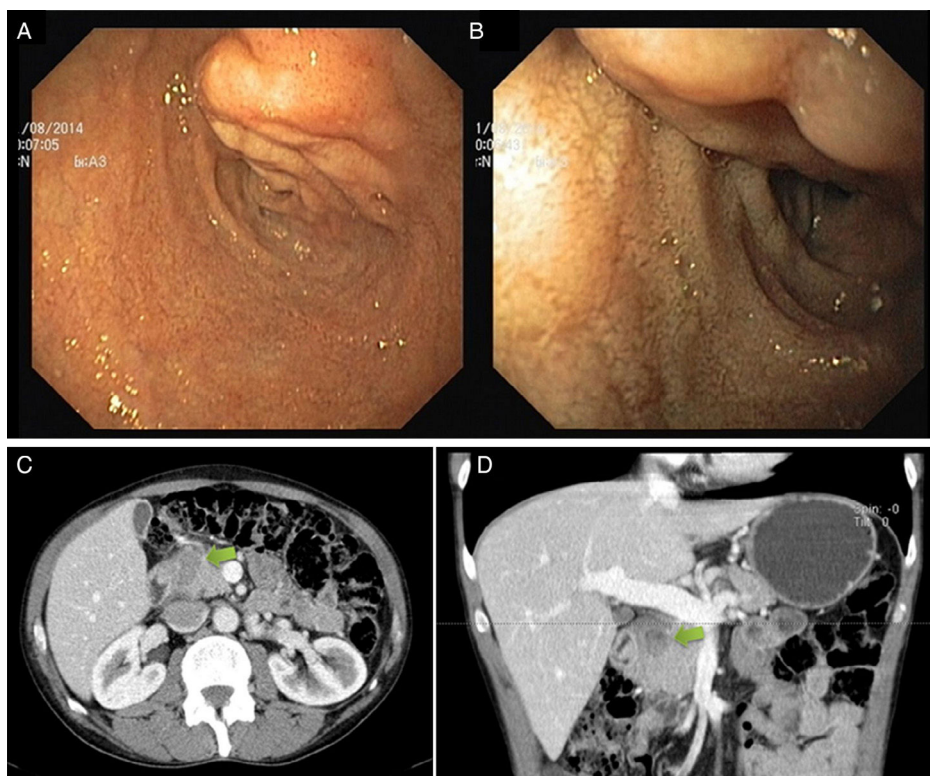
A and B) Upper endoscopy showing a tubular lesion, suggestive of vascular damage, at the upper edge of the duodenal bulb. C and D) CT scan revealing a solid and heterogeneous mass, between the duodenum and pancreatic head, with indefinite borders and no contrast enhancement.
